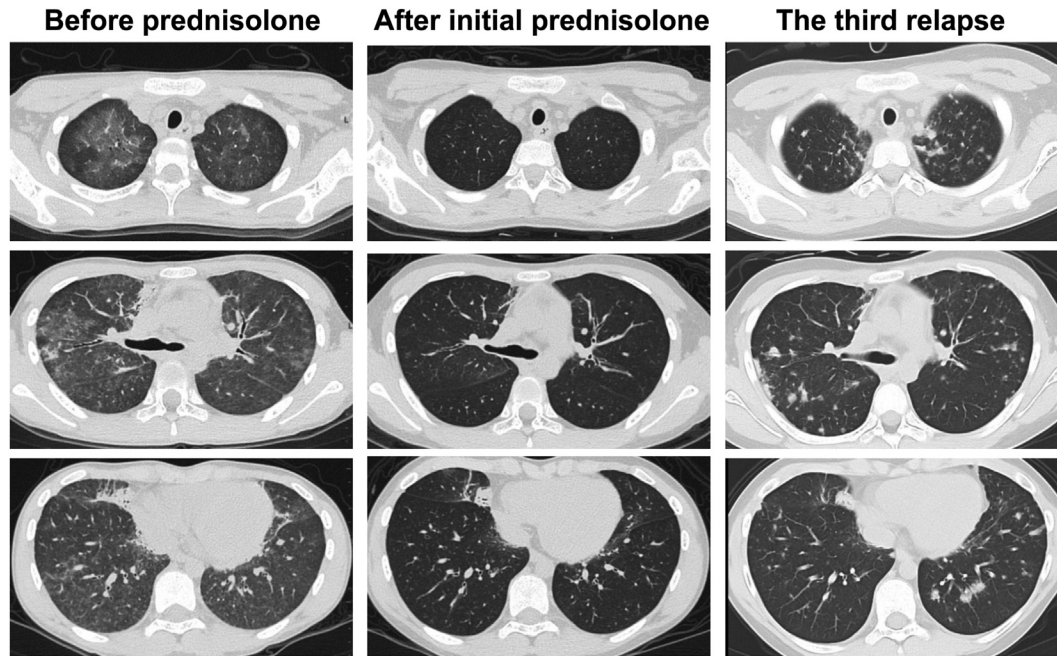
Computed tomography (CT) of the lungs. Lung CT showed ground-glass opacities that resolved after prednisolone therapy. Multiple bilateral lung nodules were present after the third relapse of pneumonia.
